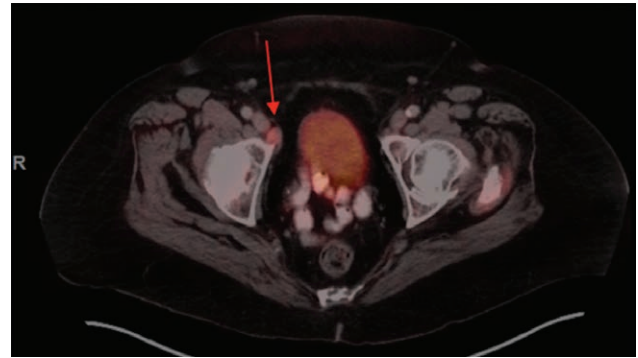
PET/CT scan completed in June 2019 showing a hypermetabolic lymph node along the course of the distal right external iliac vessels.
